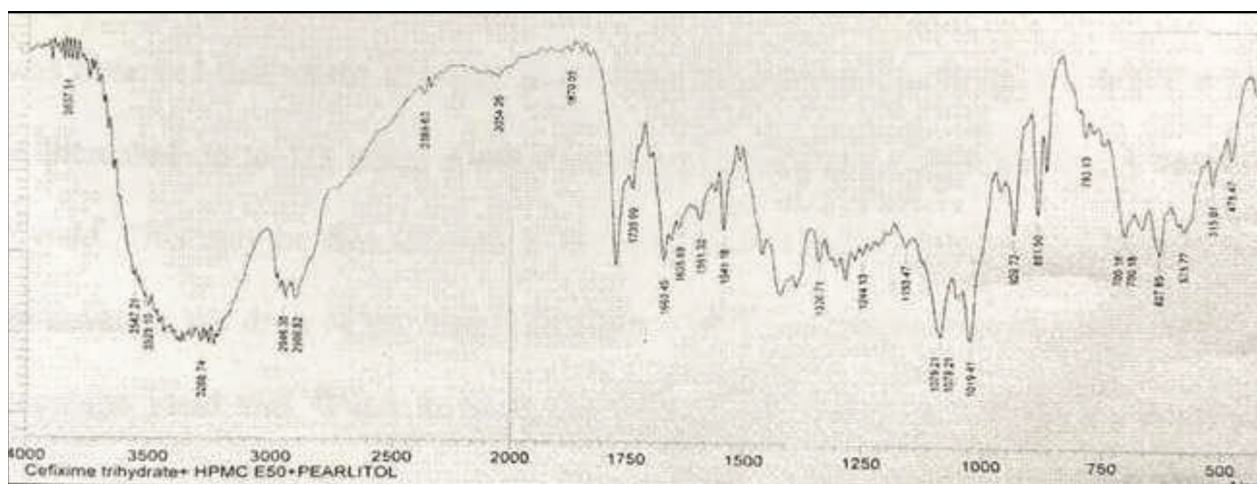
FTIR of FF12 ODMTs (CT + optimised hydroxypropyl methylcellulose E50 microcapsules + pearlitol)
